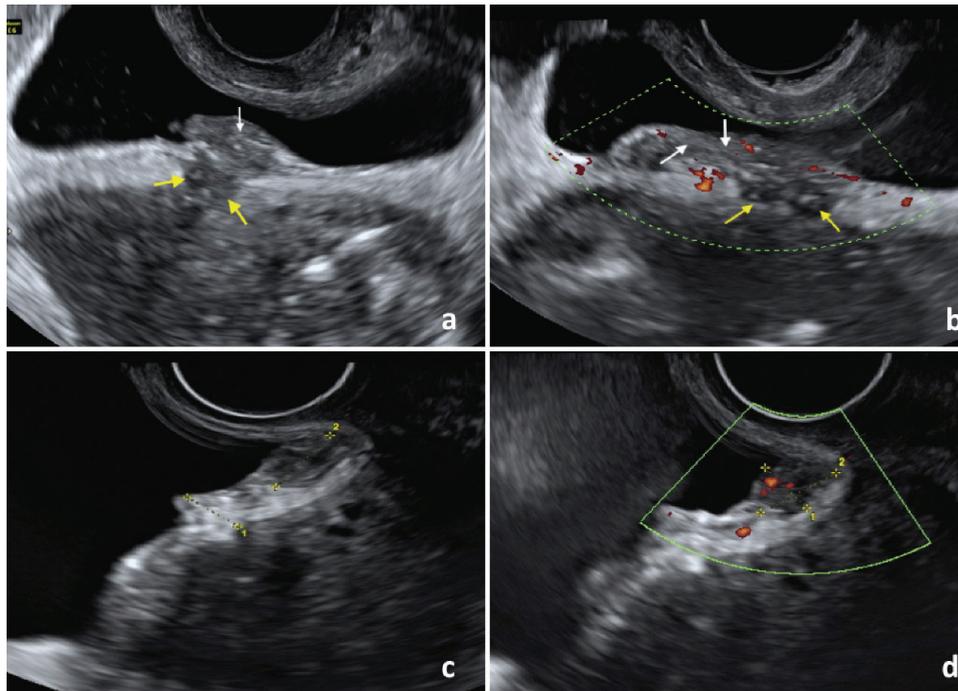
Residual endometriosis of the bladder wall after bladder resection for deep endometriosis TVS (view of the same case): a) 2D grey scale transverse view of the bladder; b) longitudinal view of the bladder lesion with power Doppler. Note the hypoechoic non-vascularized (white arrows) lesion interrupting the bladder wall and the surrounded hyperechoic fibrotic tissue (white arrows). In c) and d) another case of residual endometriosis in 2D grey scale c) and power Doppler view d). Note in c) the hypoechoic lesion the bladder wall attached to the uterus (yellow line 2) and the surrounded hyperechoic fibrotic scar tissue (yellow line 1). In d) the hypoechoic endometriotic lesion showed few vessels at power Doppler (yellow line 1 and 2) consistent with active endometriosis
